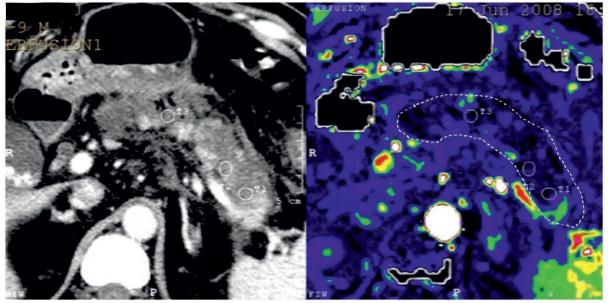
Color map of perfusion CT imaging in a patient with acute necrotizing pancreatitis in the early stage of ANP. Contrastenhanced CT (CE-CT) showed diffuse enlargement of the pancreas with slightly low enhancement (left). However, CE-CT could not clarify whether pancreas being necrotic or not. On the other hand, perfusion CT depicted necrotic area clearly as black color in the color map (right). Perfusion measurement demonstrated markedly low perfusion as 7.2 ml/ml/min in the ROI of T1.
